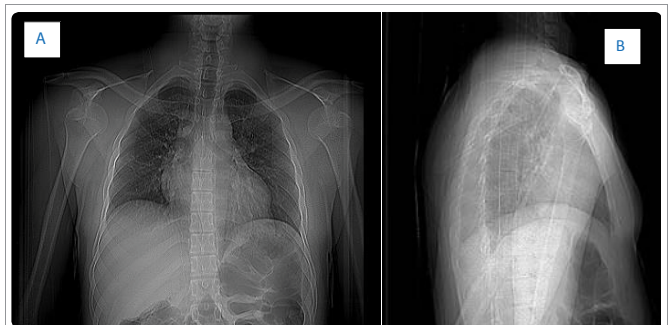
A. Y. 31 years old, face (A) and profile (B) standard x-rays: simultaneous recent anterior internal bilateral dislocation.
